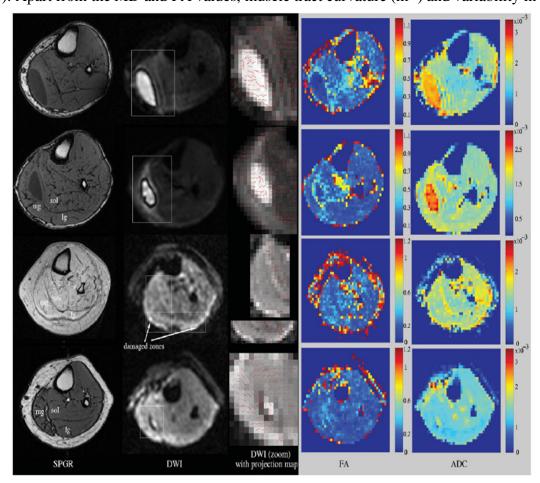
Axial images of the human calf muscles with different types of injury. First row: patient PS1 with 1-day-old acute gross intramuscular hematoma injury; second row: patient with five-day-old gross intramuscular hematoma injury; third row: patient with clinically apparent acute medial gastrocnemius tear injury; and fourth row: patient PS4 with clinically apparent chronic gastrocnemius tear injury. Within each row the images are shown in the following order: high contrast T1-weighted image obtained using the SPGR pulse sequence, DWI image, fragment of the DWI image showing the damaged area with 2D projection map (see text for details), the FA map, and the ADC map. The frames on DWI images, they are: sol, lg, and mg. FA is dimensionless and units for ADC are mm²/second. [Zaraiskaya 2006.]
